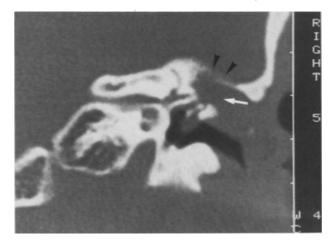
Post contrast CT scan: erosion of the tegmen tympani (*black arrows*). A non contrast-enhanced soft-tissue mass (*white arrow*) fills the attic cavity without ossicular chain erosion
